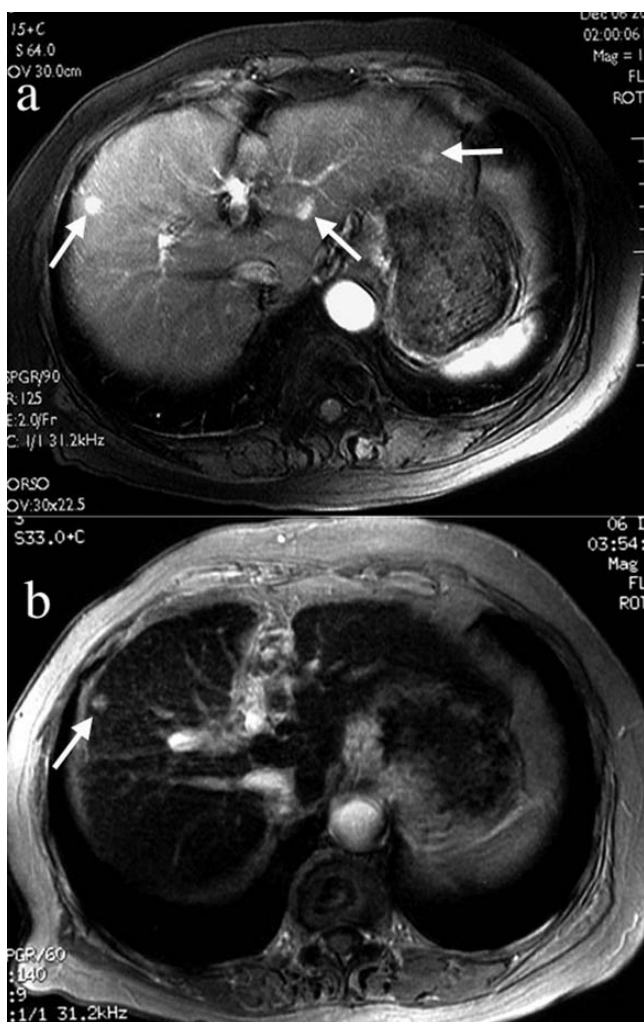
HCC in a 71-year-old male: dynamic MR imaging vs SPIO-enhanced MR imaging. On dynamic MR imaging (a), multiple enhancing lesions are noted in the liver (arrows). SPIO-MR imaging demonstrated only one lesion in S8 (b; arrow). At surgery, the lesion in S8 was proven to be HCC, and the other lesions were not detected and were considered pseudolesions due to AP-shunt.
